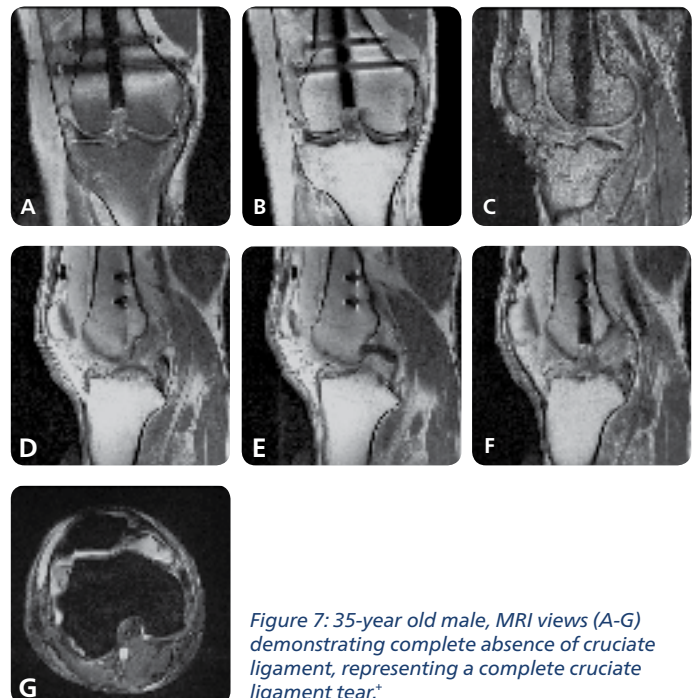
35-year old male, MRI views (A-G) demonstrating complete absence of cruciate ligament, representing a complete cruciate ligament tear.*
